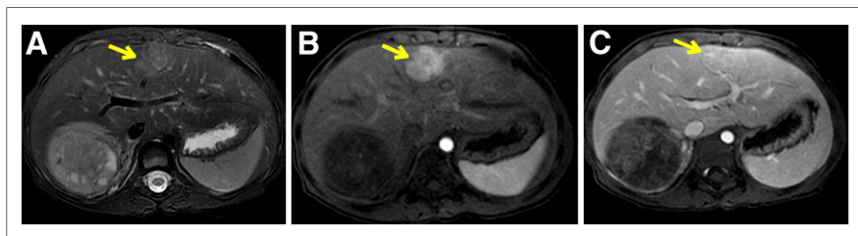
Comparison of unenhanced and enhanced MR images in patient with Wilms tumor of right kidney. (A) Before contrast administration, T2-weighted bright lesion (arrow) in right lobe of liver is suggestive of metastasis. (B) After contrast administration, early image shows arterial enhancement. (C) On delayed image, persistence of enhancement in central scar is consistent with focal nodular hyperplasia.
